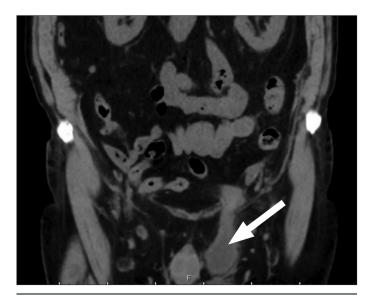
Left inguinoscrotal hernia on CT-scan without contrast
